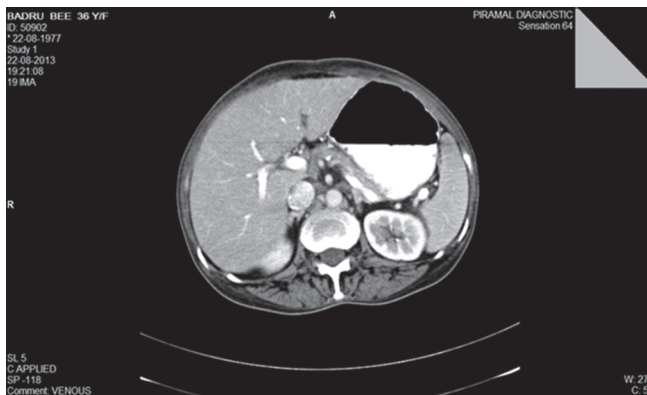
Contrast-enhanced computed tomography abdomen showing no abnormality in liver or biliary tracts
